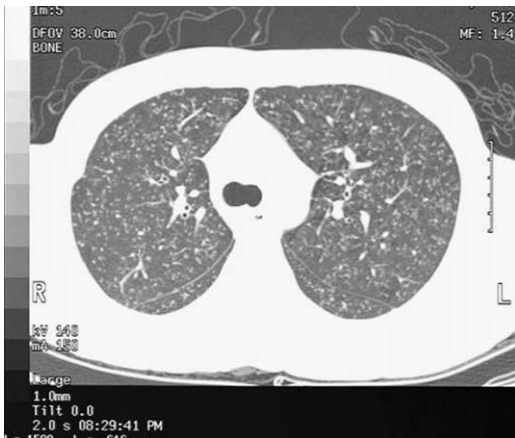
CT scan of miliary tuberculosis.
